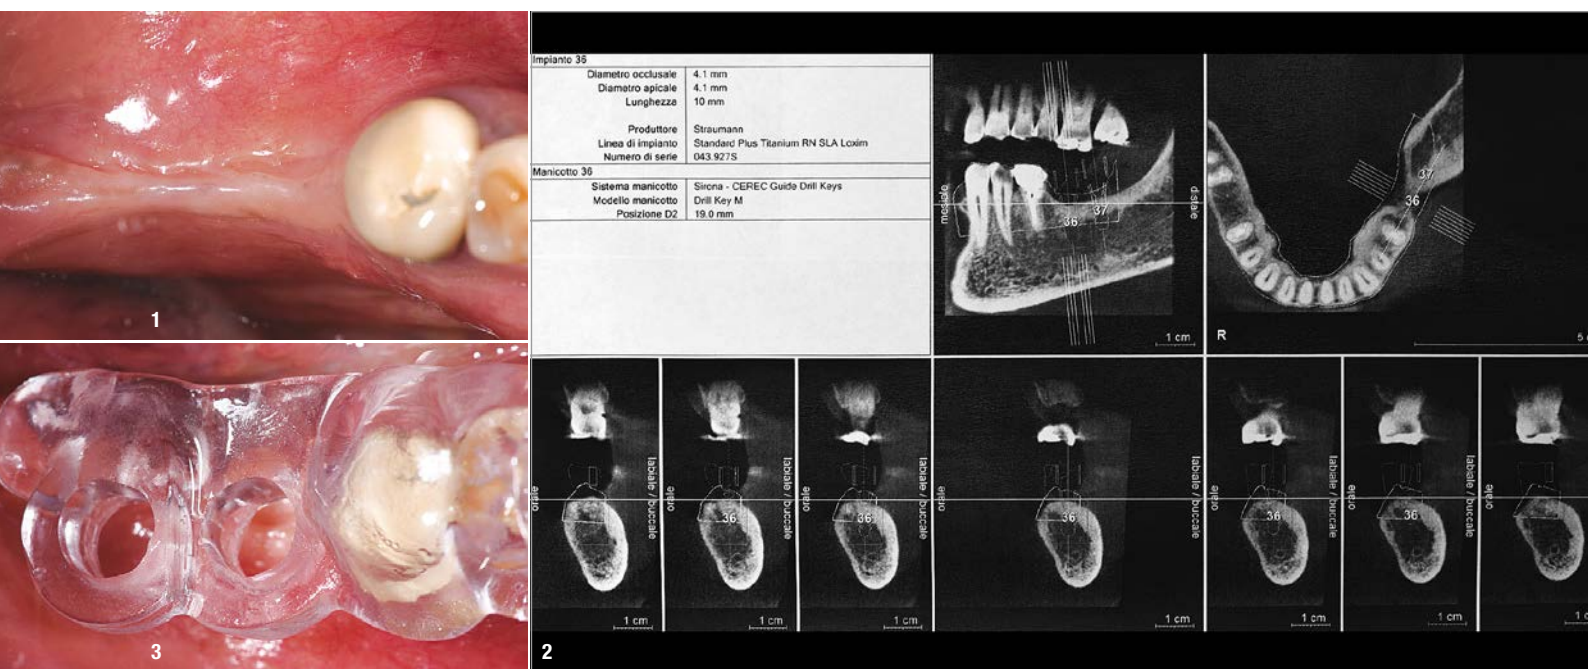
Pre-surgical situation, shows the lack of connective tissue and residual bone atrophy. To be taken into account when comparing the result obtained after completion of the implant restoration. Fig. 2: Representative axial sections of CBCT at sites of surgical interest. Fig. 3: Positioning of the surgical template for correct implant placement in the transverse space and axial direction.
